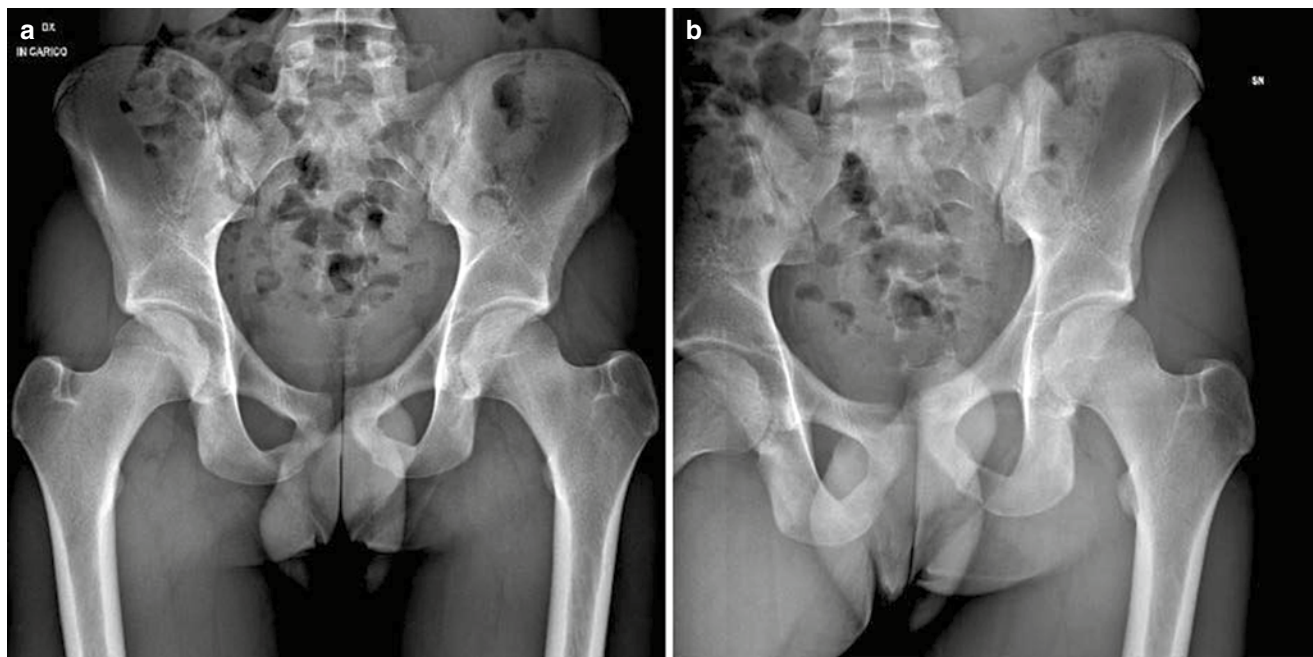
A double-stance X-ray (a) compared to a dynamic flamingo view X-ray (b) made in alternating single-stance support (in this case in single right stance). The subject, a 25-year-old professional football
